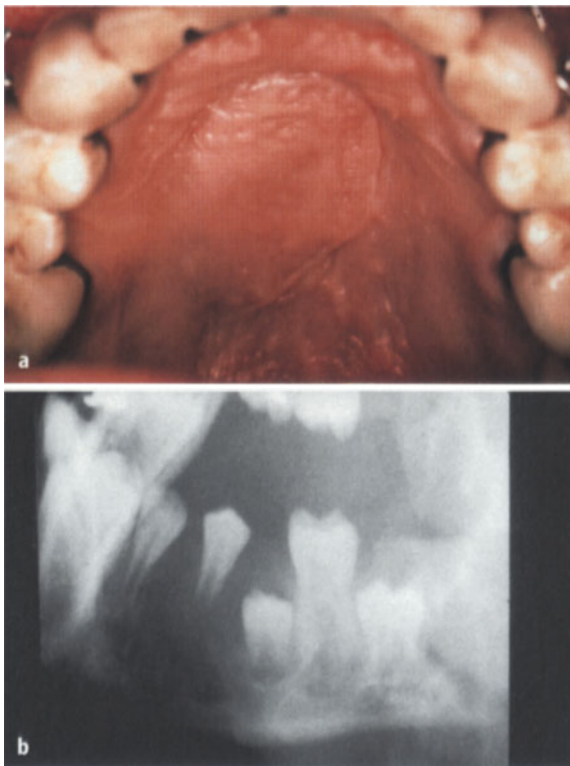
a Giant-cell granuloma on the hard palate and b radiographic findings in another patient with a similar tumor
